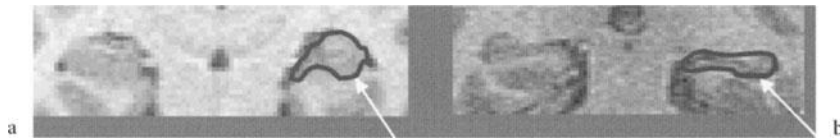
Magnetic resonance imaging (MRI) scan of the hippocampus in a a normal control and b a patient with PTSD secondary to childhood abuse. The hippocampus (*outlined*) is
